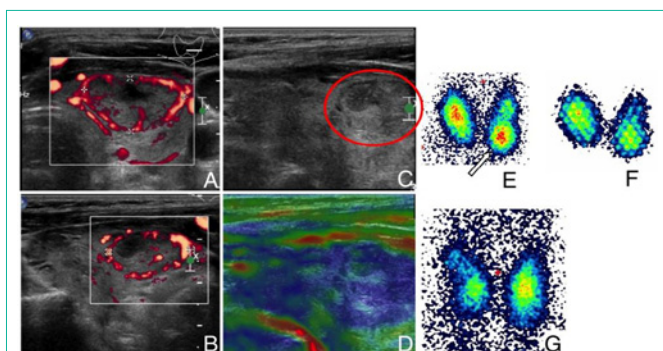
Thyroid nodule lower left lobe (multifocal autonomy): A: Axial; B: sagittal; C: sonography showing increased perfusion; D: sagittal sonography corresponding to the elastography (nodule marked in red), the elasticity is hard. E: The scintigraphies show the multifocal autonomies (arrow point at the mentioned nodule) before radioiodine therapy; F: during radioiodine therapy; G: At follow-up, the scintigraphy shows a thyroid without the previous multifocal autonomies.
